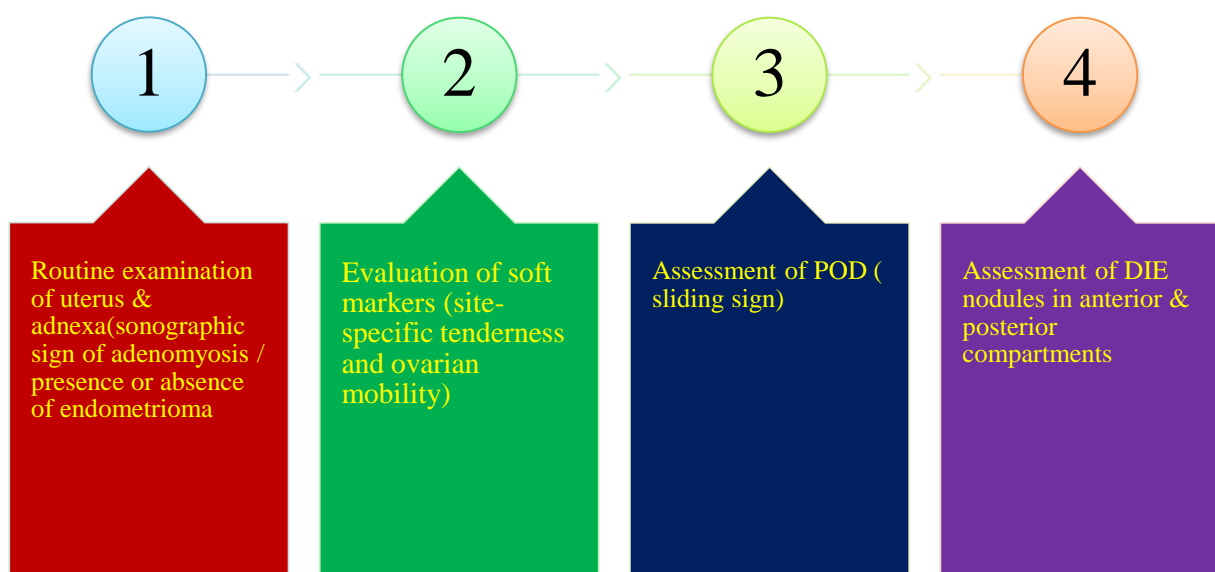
Four basic sonographic steps when examining women with suspected or known endometriosis.³
